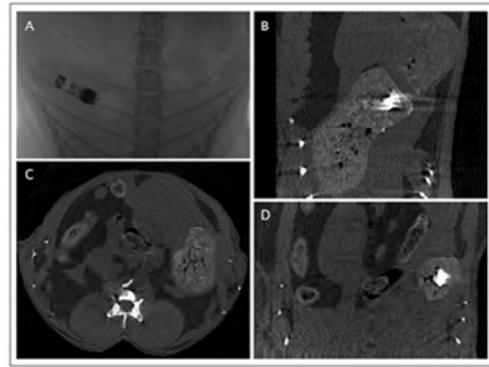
In vivo CT images of capsule disrupted in stomach. A: 2D projection image at 2 hour; B-D: 3D reconstructed image at 5 hour time point (coronal view, axial view and sagittal view).
